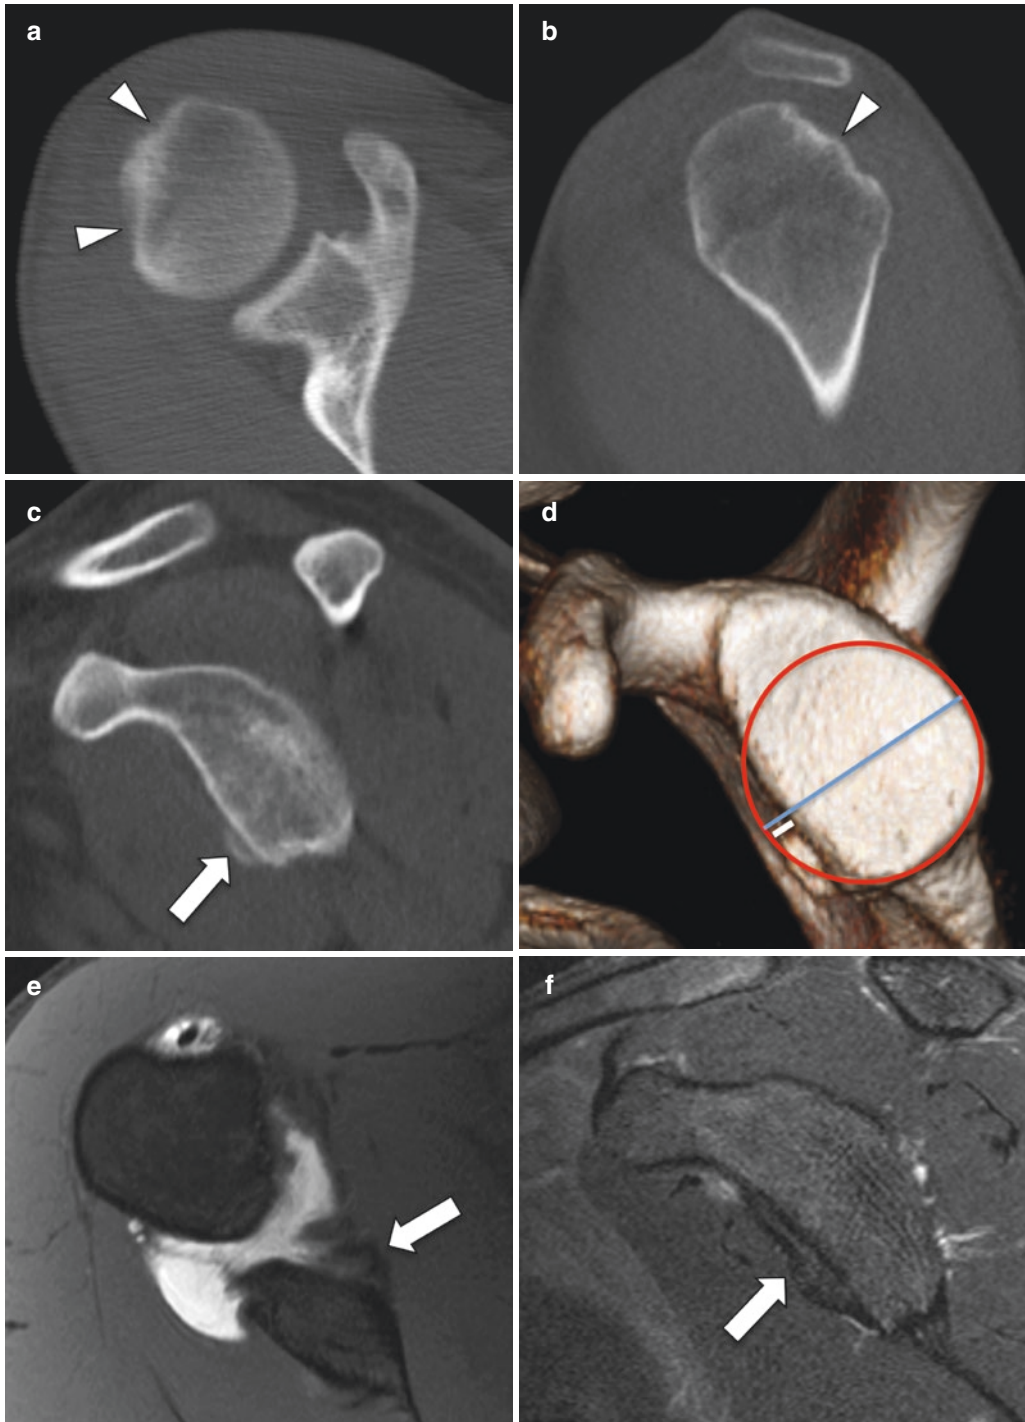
Bankart and Hill-Sachs fractures. Axial (a), sagittal CT reformats (b and c), and 3D reconstruction of the glenoid (d) demonstrating Hill-Sachs (arrowheads) and Bankart fractures (thick arrows). Axial fat-saturated T1-weighted (e) and sagittal fat-saturated T2-weighted (f)
